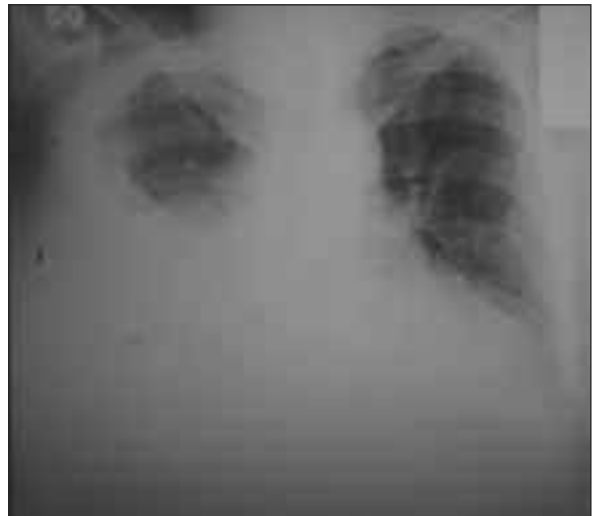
Chest x-ray showed a homogenous density increase due to pleural effusion covering the sinuses and effacing the diaphragm and cardiac contour in the right lower zone.
